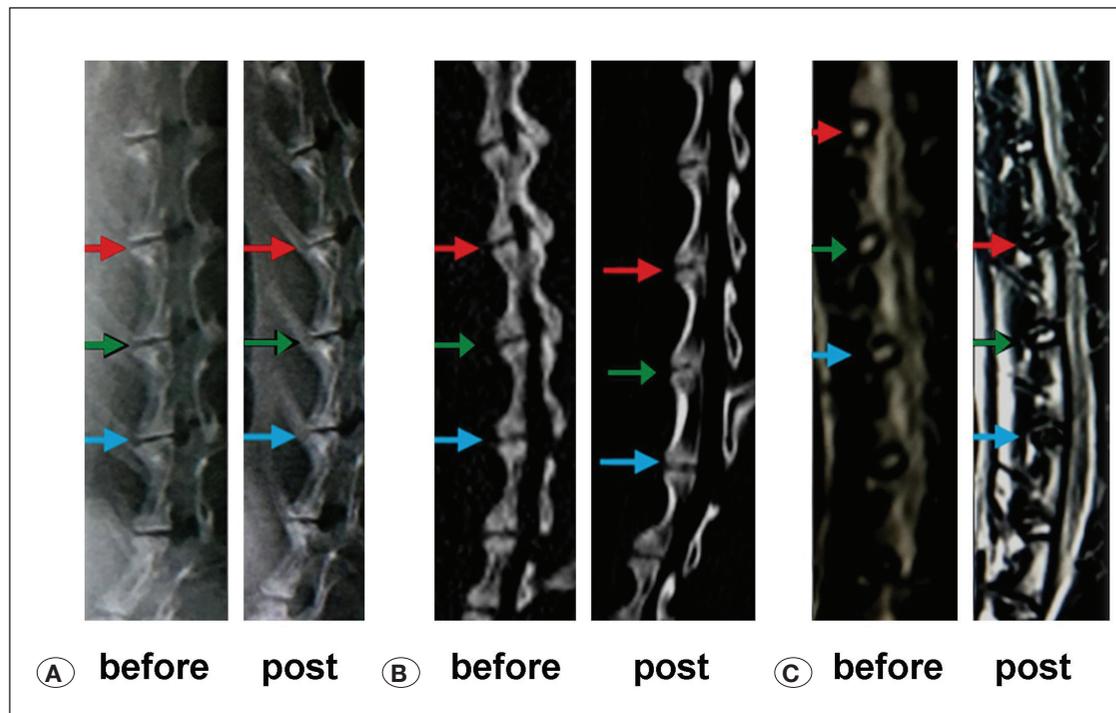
Comparison of the preoperative and postoperative X-ray, computerized tomography (CT), and magnetic resonance imaging (MRI) at six weeks. A) X-ray before/post operation. B) CT before/post operation. C) MRI before/post operation. L3/4 annulus puncture: blue arrows, L4/5 untreated operation: green arrows, and L5/6 nucleoplasty: red arrows.
